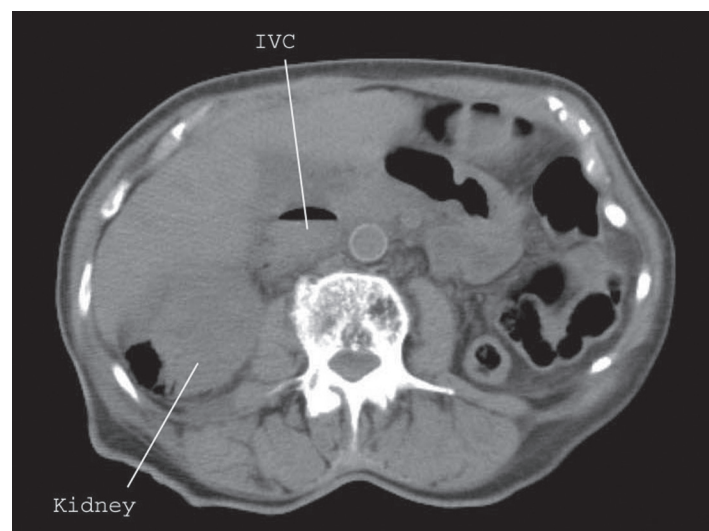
Additional non-contrast computed tomography image highlighting extensive emphysematous pyelonephritis with pneumo-vena cava. IVC signifies inferior vena cava.
